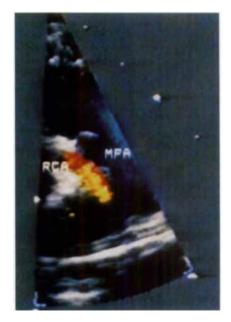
Color Doppler study of the same view as in Figure 1. Legend as in Figure 1. Note retrograde flow from RCA into MPA.
